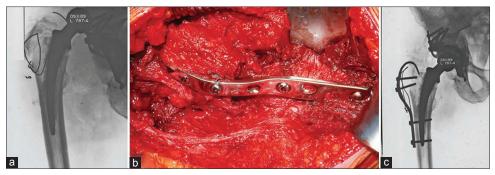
A 74-year-old male patient underwent a primary right total hip arthroplasty for severe degenerative joint disease. (a) X-ray hip joint with proximal thigh anteroposterior view showing an acetabular revision via a transtrochanteric approach for dislocation secondary to acetabular component malposition, the patient developed a symptomatic nonunion of the greater trochanter. (b) Peroperative photograph showing that the trochanteric nonunion of 2–3 cm of displacement with poor bone stock was fixed because of moderate to severe hip pain and limping. (c) Intraoperative fluoroscopy imaging following trochanteric reconstruction with the articulated hook plate and iliac crest bone grafting demonstrated good positioning of the implant
